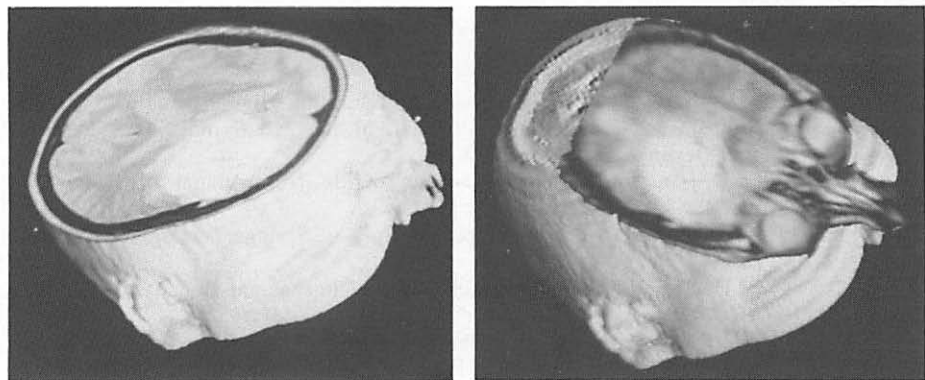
Interactive selection of a target and a trajectory on MR images. Reconstructed oblique sections are superimposed on a 3D display of the head (obtained by processing 20 MRI slices)
